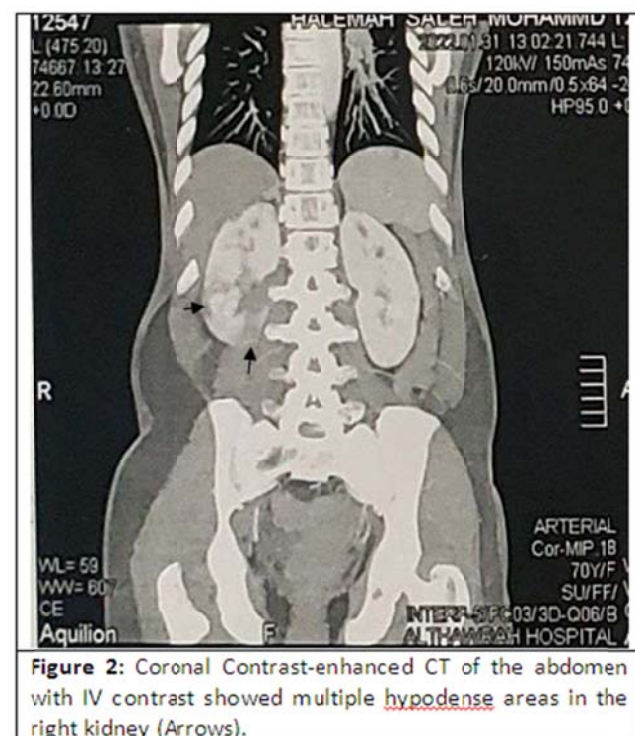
Coronal Contrast-enhanced CT of the abdomen with IV contrast showed multiple hypodense areas in the right kidney (Arrows).
